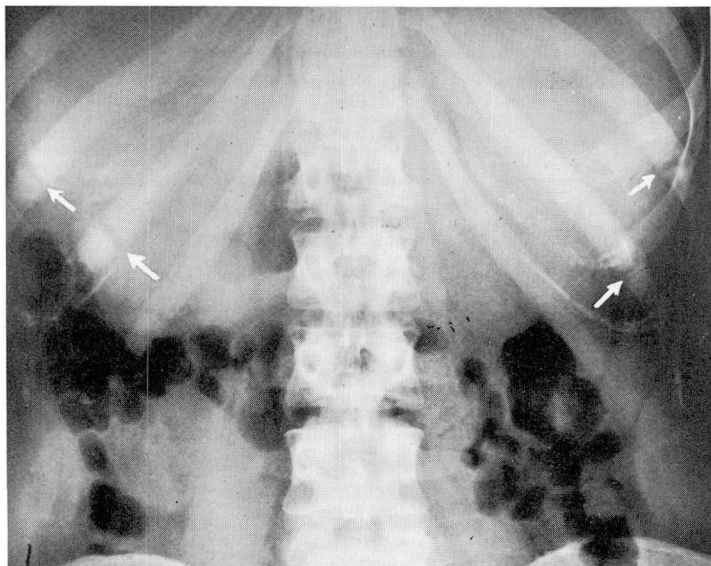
Roentgenogram showing bilateral Looser's lines (arrows) in the tenth and eleventh ribs. There is no evidence of displacement of fragments.
